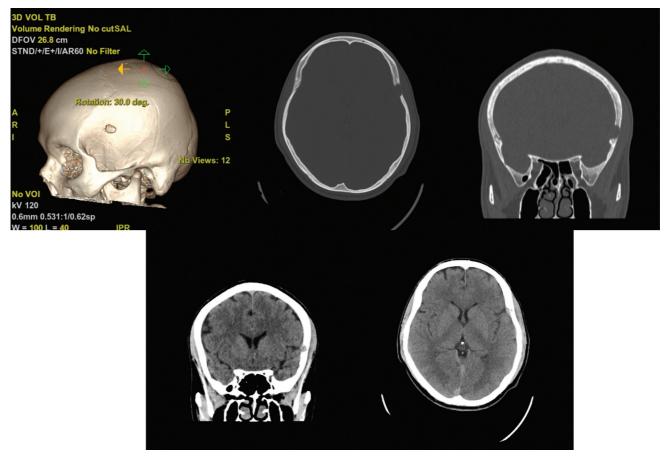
Head computed tomography scan with 3D reconstruction. Axial and coronal views of the bone and brain windows are shown, in which a lytic lesion measuring approximately 17 mm in its anteroposterior diameter that affects the left temporal bone is visualized. A solid component of the lesion is also observed, which initially seems to arise from the adjacent meninges.
